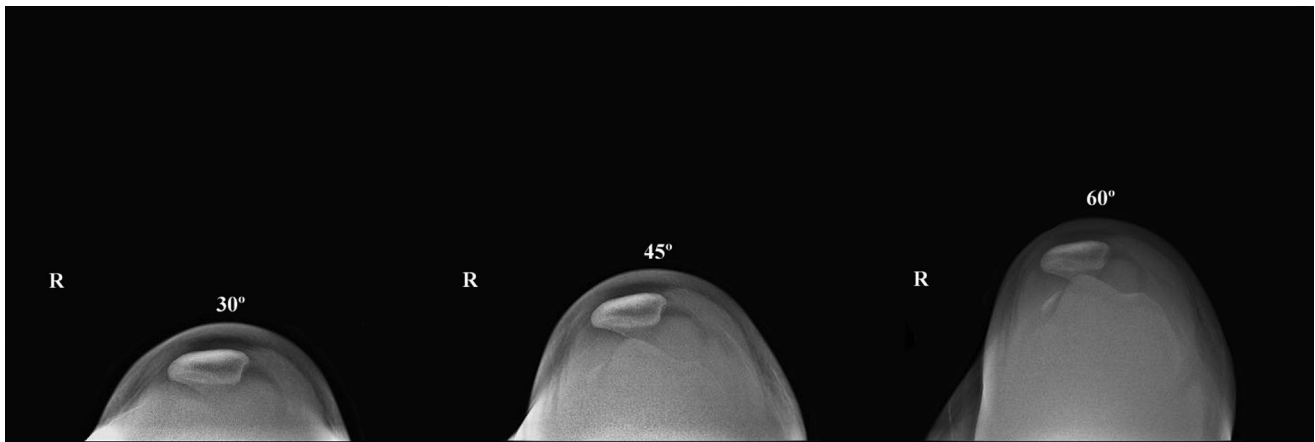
Axial radiographs of the right knee at 3 different flexion angles.
